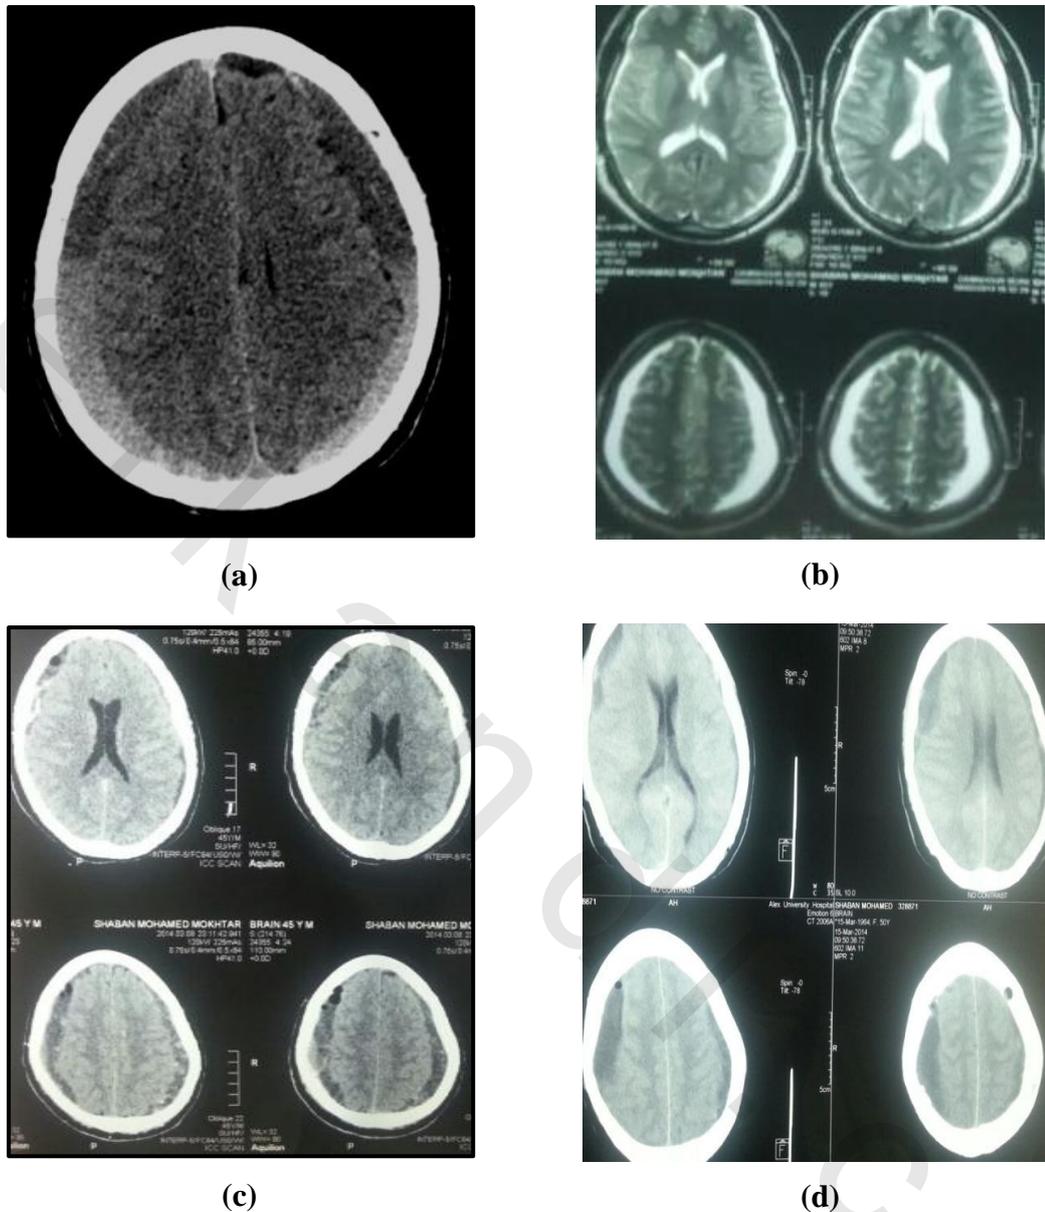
CT images. (a) Initial CT with a left-sided chronic subdural hematoma of the laminar type in 69 years male patient on oral anticoagulant. (b, c) CT brain done after evacuation of the CSDH using one bur hole and subcutaneous closed system drainage showing massive subdural air collection and large mid-line shift. Subdural air resolved gradually with flat head position and adequate fluid intake. (d) CT brain done 2 months after discharge of the patient because of recurrence of the symptoms (headache and right hemiparesis) showing recurrent CSDH.
